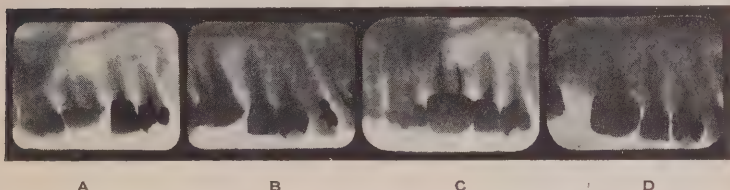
(a) Abscess with sinus on mesiobuccal root of upper first molar with area of rarification, Feb. 1920; (b) root filled and radiographed March 9, 1920; (c) appearance of improvement of bone between the mesial root and the bicuspid and remaining circumscribed area of rarification; (d) appearance Jan. 30, 1925. Note: Gradual improvement over a period of four years following short medication and copper amalgam root fillings.
